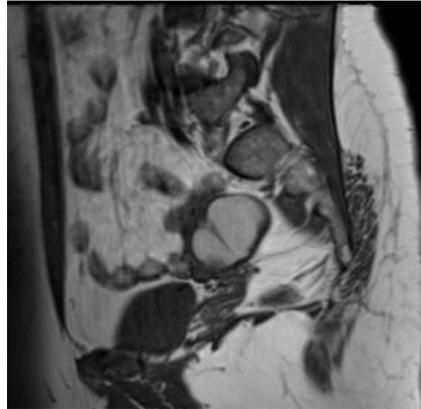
Sagittal T1-weighted image shows a well-defined, hyperintense, cystic lesion in the right ovary measuring ~ 4x2.8x3.4 cm.
